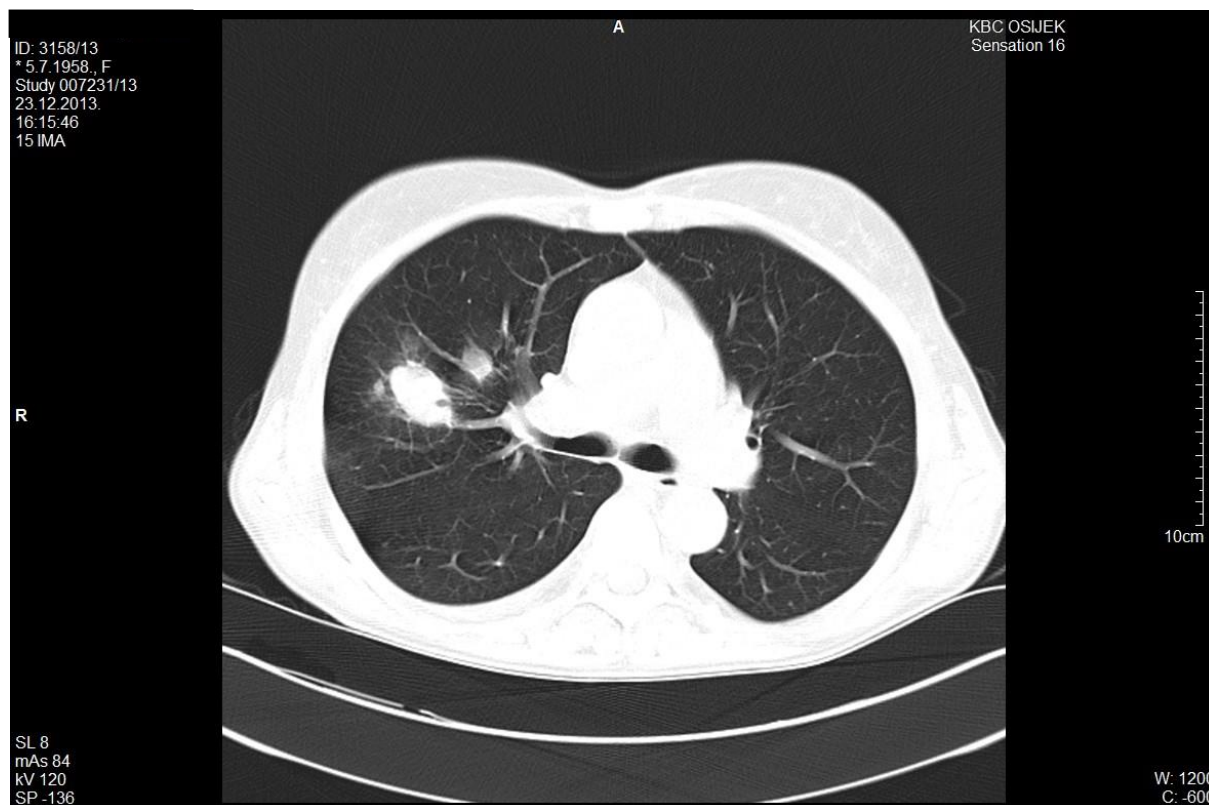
CT image of the patient's thorax with a solid soft tissue opacity in the right middle zone of the lungs
